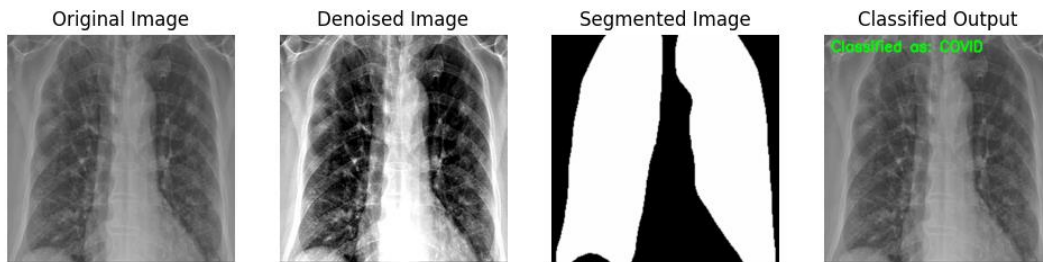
Predicted Outcome on CXR as COVID-19 by Proposed CT-CXR-Net.
